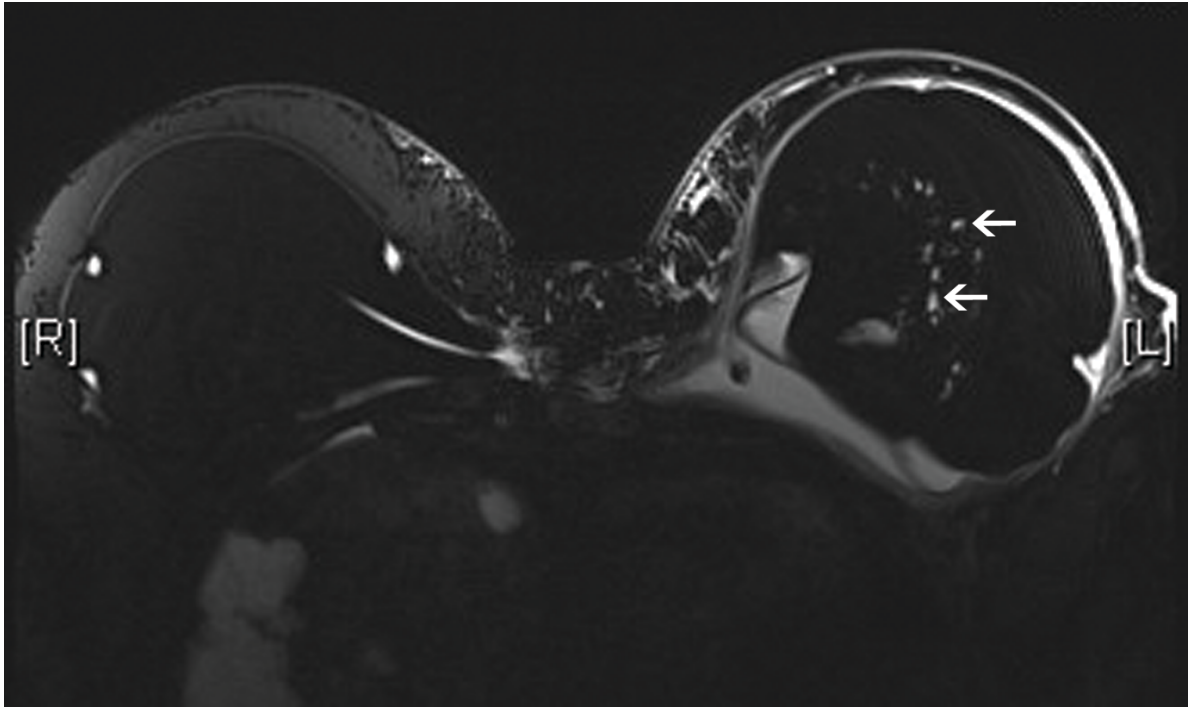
Magnetic resonance imaging showing the breach of the envelope at the deep aspect of the implant. Multiple areas of water signal content are noted within the silicone in the implant
